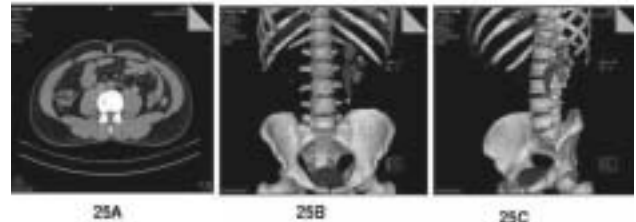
A,B & C: Noncontrast CT (A) depicting a left ureteric calculus. CT urogram using volume rendering (B, C) shows the pelvicalyceal system to be bifid and the calculus in the upper left ureter.
